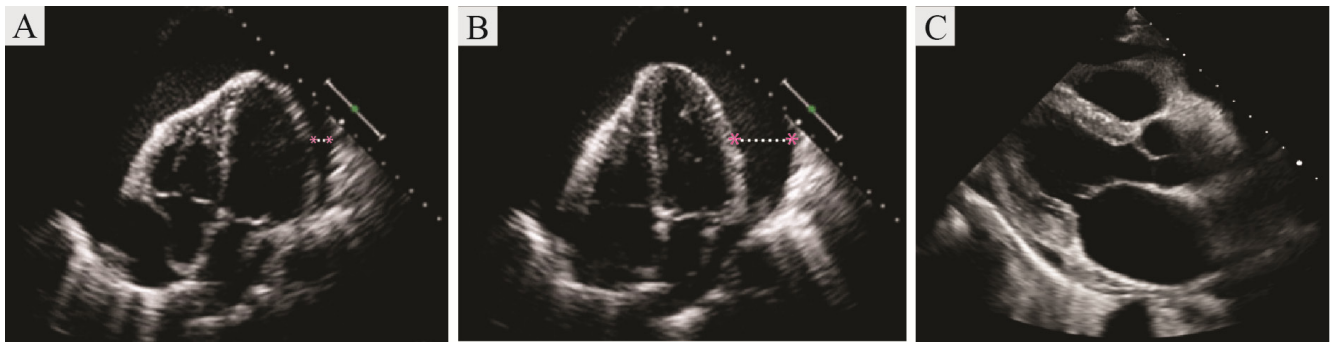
The images present the transthoracic echocardiography of Case II. A & B) The apical 4-chamber view demonstrates a sizable pericardial effusion and a swinging heart. C) The parasternal long-axis view demonstrates a mild pericardial effusion 2 months after the procedure.
